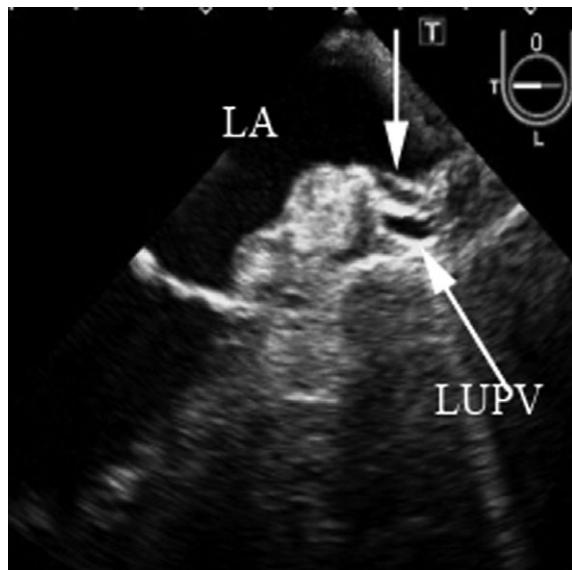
Transesophageal echocardiography (TEE) helps localize each of the PVs for insertion of the St. Jude Reflexion Spiral catheter (SJRS) (arrow) to obtain PV electrograms.
